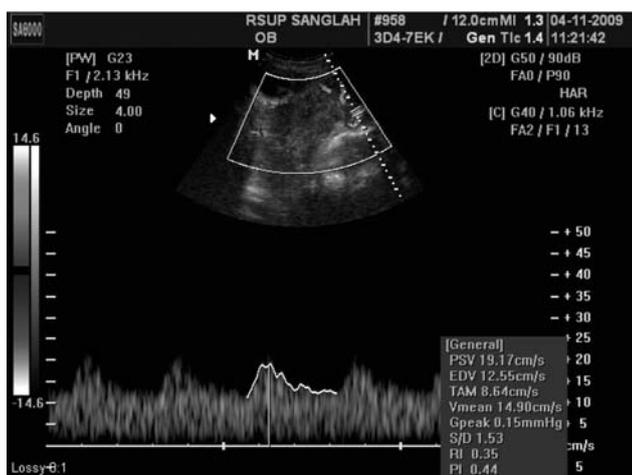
The Doppler appears in the non operable cervical cancer intratumoral vessels which are excessively seen.
